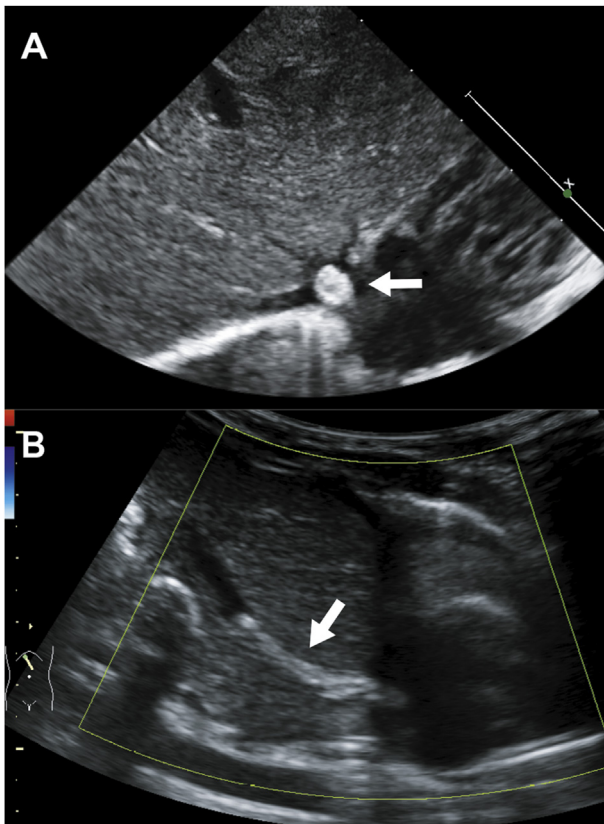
A follow-up echocardiogram revealed a hyper-echoic oval lesion (6×5 mm) inside the inferior vena cava (IVC) in the transverse view of the IVC on the ninth day of life (A). Another abdominal ultrasonogram showed a heterogeneous, hyperechoic tubular structure (28×4.5 mm) from the confluence of the hepatic veins to the left portal vein in the left lobe of the liver; however, no splenomegaly or ascites were noted (B).
